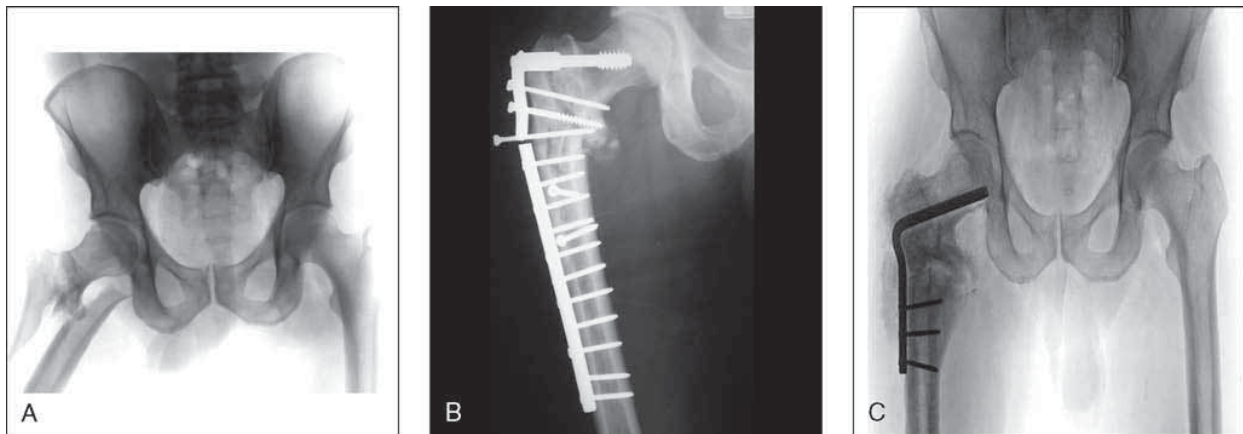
A, Radiograph of a right pertrochanteric hip fracture sustained by a 50-year-old man in a high-speed motor vehicle collision. B, At 6 months, the fracture was not united, and the hardware had failed. C, After hardware removal, the nonunion was repaired with a compression blade plate.
